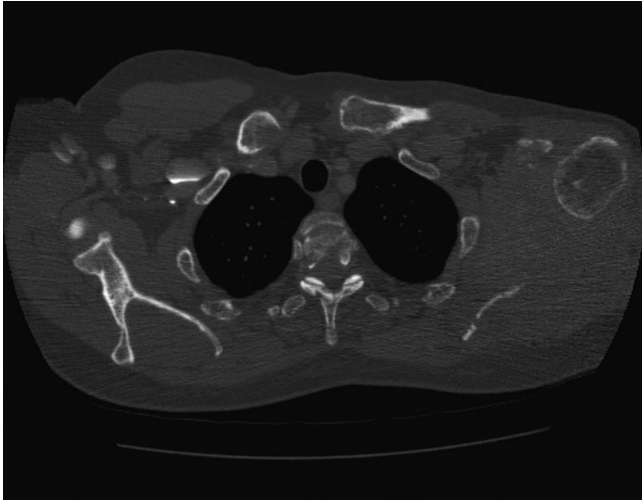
59-year-old male with myeloma. Contrast-enhanced CT scan of the thorax. The left scapula was almost entirely missing. It was replaced by a large, homogeneous soft-tissue mass that was biopsied, confirming the diagnosis of myeloma.
